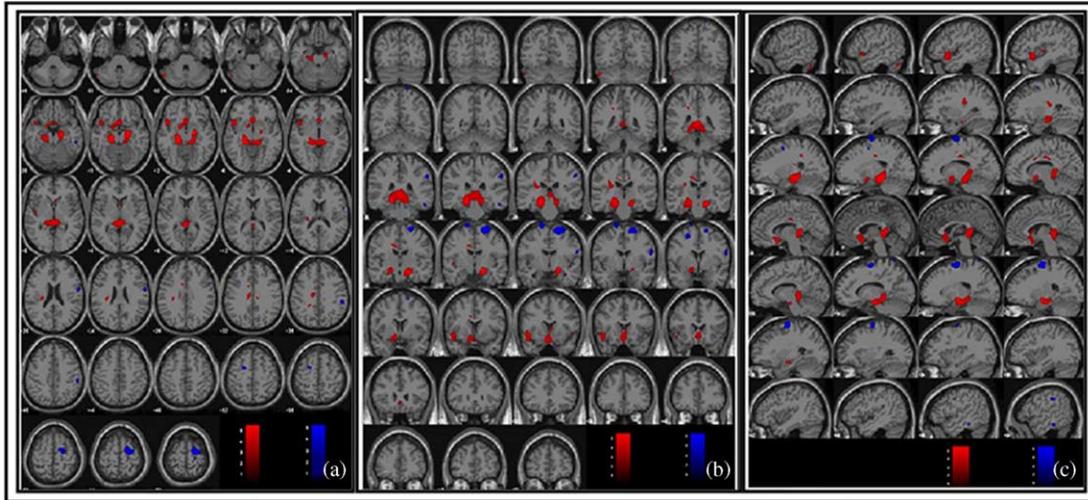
(a) Axial, (b) coronal, and (c) sagittal SPM images on template T1 weighted high-resolution brain MRI. Brain regions of increased (red) and decreased (blue) rCBF levels in PTSD patients ($n=23$) compared with normal controls ($n=64$) are shown.
